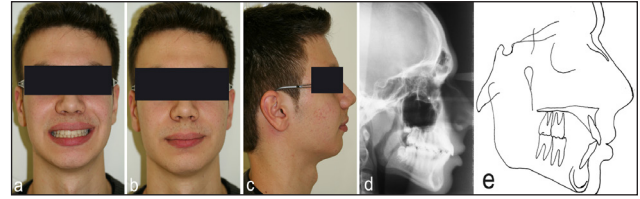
Patient's facial appearance after therapy a) smile, b) front face, c) profile, d) lateral head radiograph after therapy, e) cephalometric tracing after therapy.
